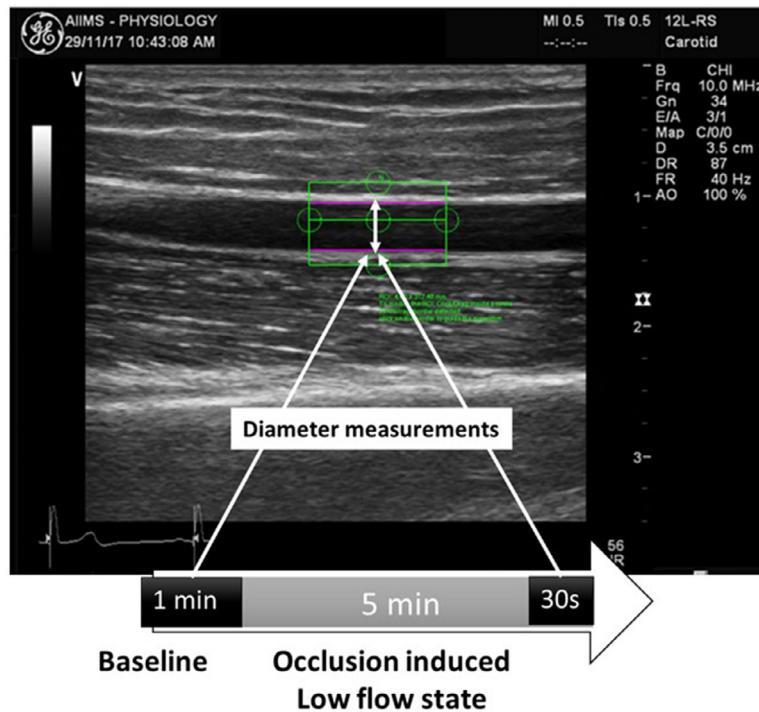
A representative ultrasound image along with the recording protocol. The green rectangle indicates the region of interest marked for automated edge detection and diameter measurements using Brachial Analyzer. The pink lines mark automatically detected lumen-intima interface identified by the software. End-diastolic diameters were measured during 1 min of baseline recording and the last 30 s of the phase of occlusion.
